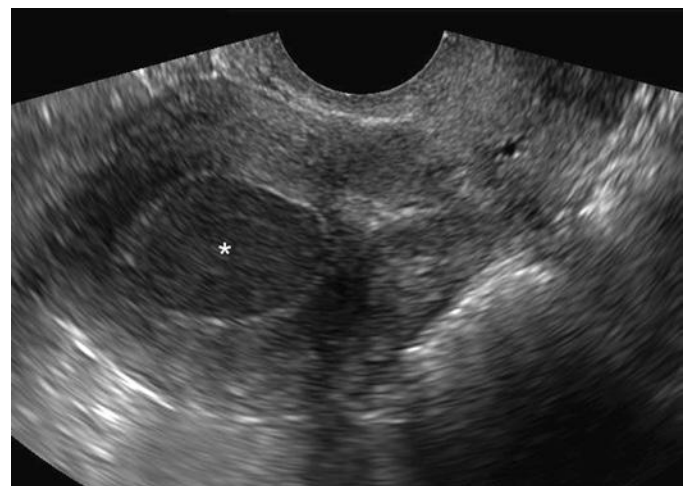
Hematometra following incomplete endometrial ablation. This 51-year-old patient presented with crampy pelvic pain but no bleeding. Transvaginal sagittal image of the uterus demonstrates the endometrial cavity distended with homogeneous hypoechoic material (asterisk) that was avascular on color Doppler imaging (not shown). The patient spontaneously bled and decompressed 1 day before her planned cervical dilation.
